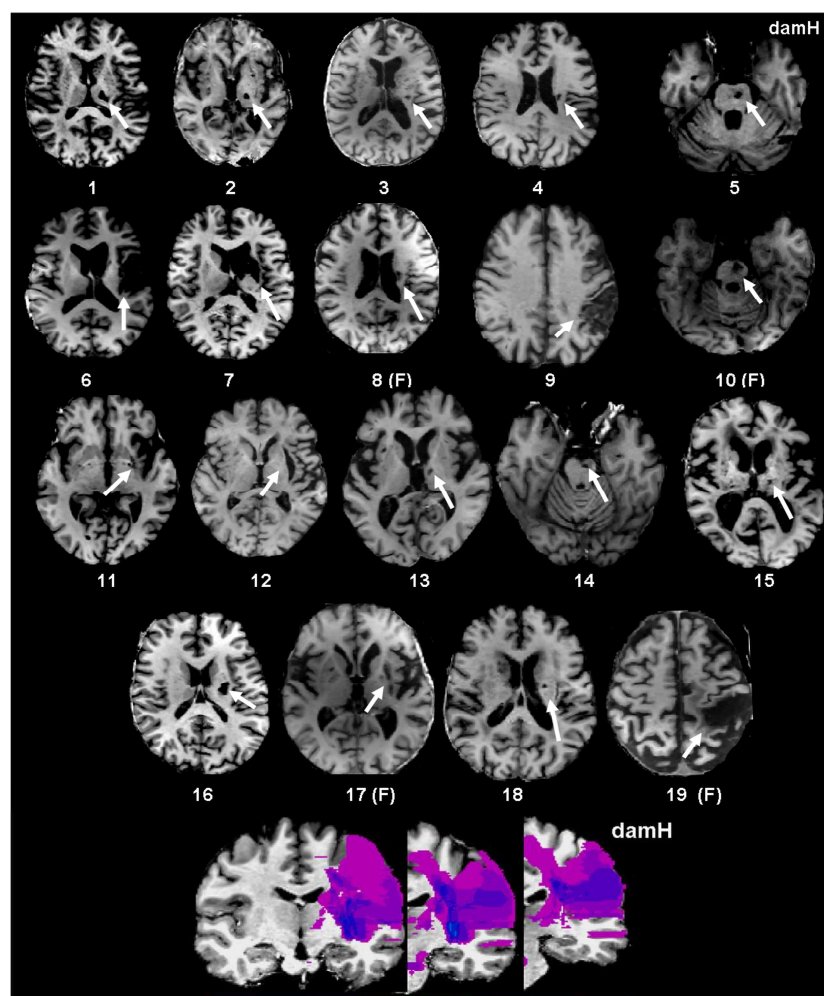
Stroke localisation and overlap. Upper panel: T1 magnetic resonance imaging (MRI) at the level of the main stroke injury. Lower panel: patient's lesion overlap symbolised by the colour scale (created with MRlcro 1.4). Purple represents the stroke area of a single patient, green represents localisation shared by half of the patients, and red indicates localisation shared by all of the patients. For patients with lesions on the right side of the brain, the 3D-T1 MRI was flipped. The map of lesion localization and overlap was created with MRlcro 1.4. damH, damaged hemisphere. F: flipped scan.
